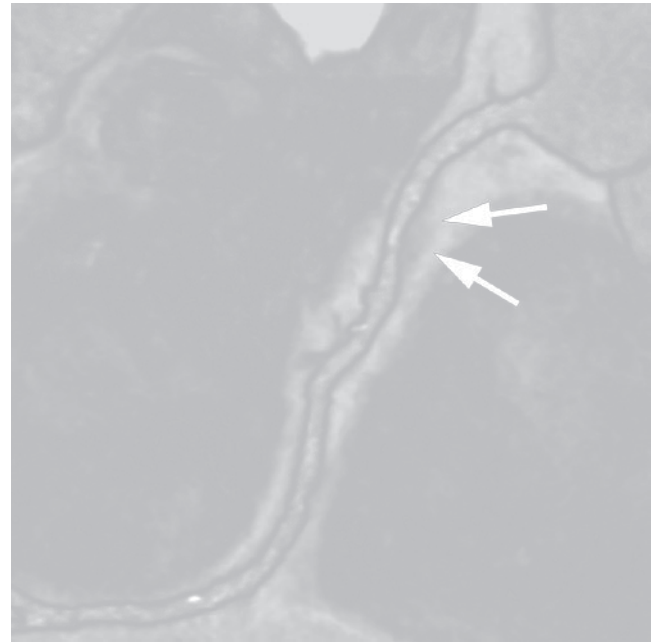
Visualization of nonobstructive coronary atherosclerotic plaque by CT. (a) Multiplanar reconstruction of the left anterior descending coronary artery. In the proximal vessel segment, a nonobstructive plaque which is partly calcified (small arrow) and partly noncalcified (large arrow)
